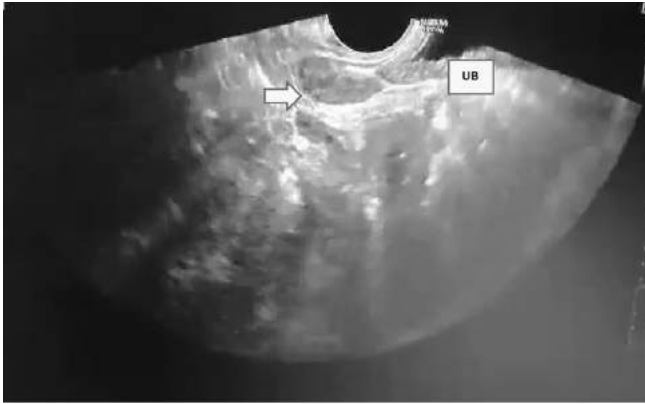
Transrectal sonogram showing the tubular muscular structure. UB- urinary bladder.
